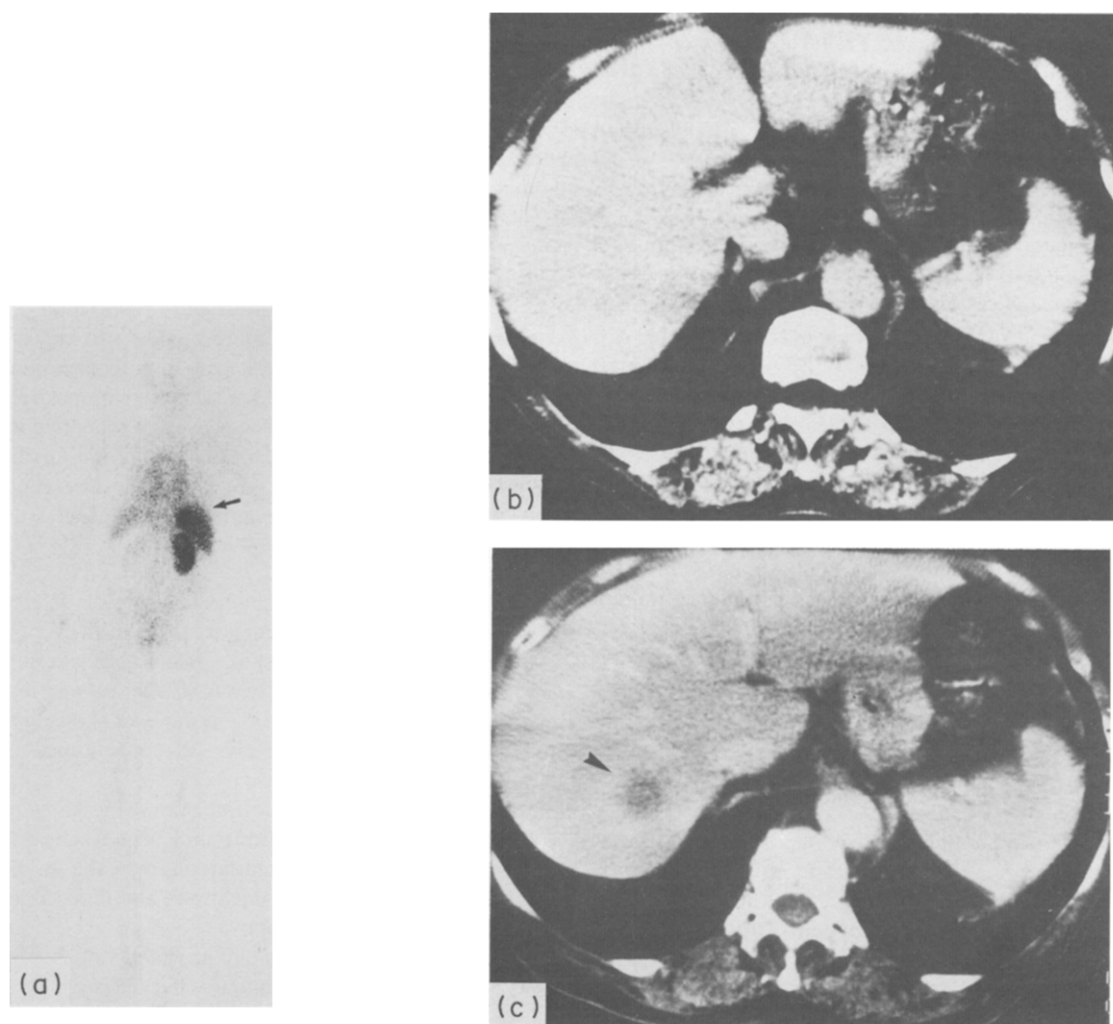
(a) Posterior planar view 22 h after injection of ^{99m}Tc -BW 431/26 in a 69 year old woman with a resected rectal carcinoma. Radioimmunoimaging detects a previously unknown metastasis in the left liver lobe (arrow). (b) The corresponding transverse CT scan did not detect any lesion. (c) CT scan 6 weeks after immunoscintigraphy reveals a solitary liver metastasis (arrow). The CT scans were kindly provided by Prof. Dr. M. Thelen, Director of the Department of Radiology, Mainz.
